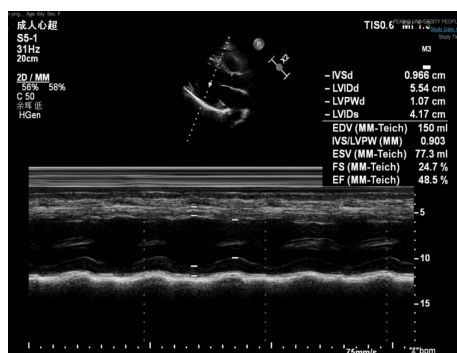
Echocardiography at the 1-mo follow-up. The size and systolic function of the left ventricle continued to recover. The ejection fraction was 48.50%.
